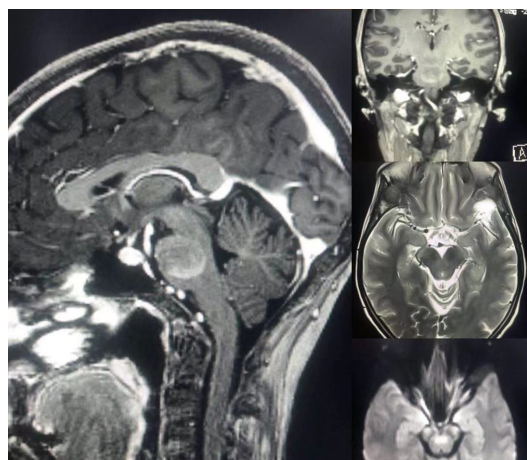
Brain MRI showing focal intra-axial lesion
